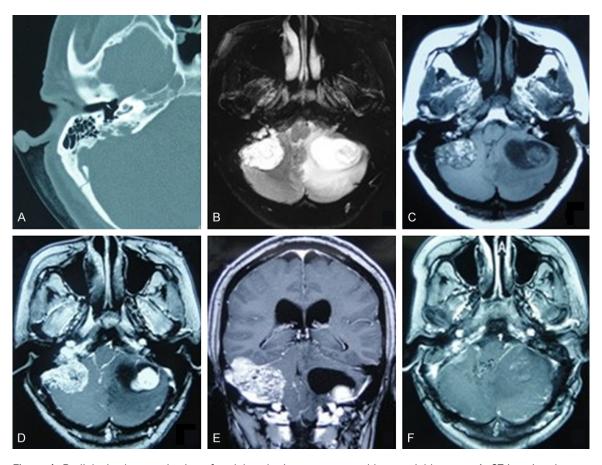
Radiologic characterization of endolymphatic sac tumor and hemangioblastoma. A: CT imaging demonstrated a destroyed petrous bone involving the right mastoid and the middle ear. B-E: MR scan showed two giant masses co-existing in the posterior cranial fossa. The right one in the CPA was irregular, heterogeneous on T1/T2-weighted images as well as heterogeneous contrast enhancement, the left lesion was shown with solid and cyst change in cerebellar hemisphere. F: MRI scan after the second operation showed totally resection of both lesions.
